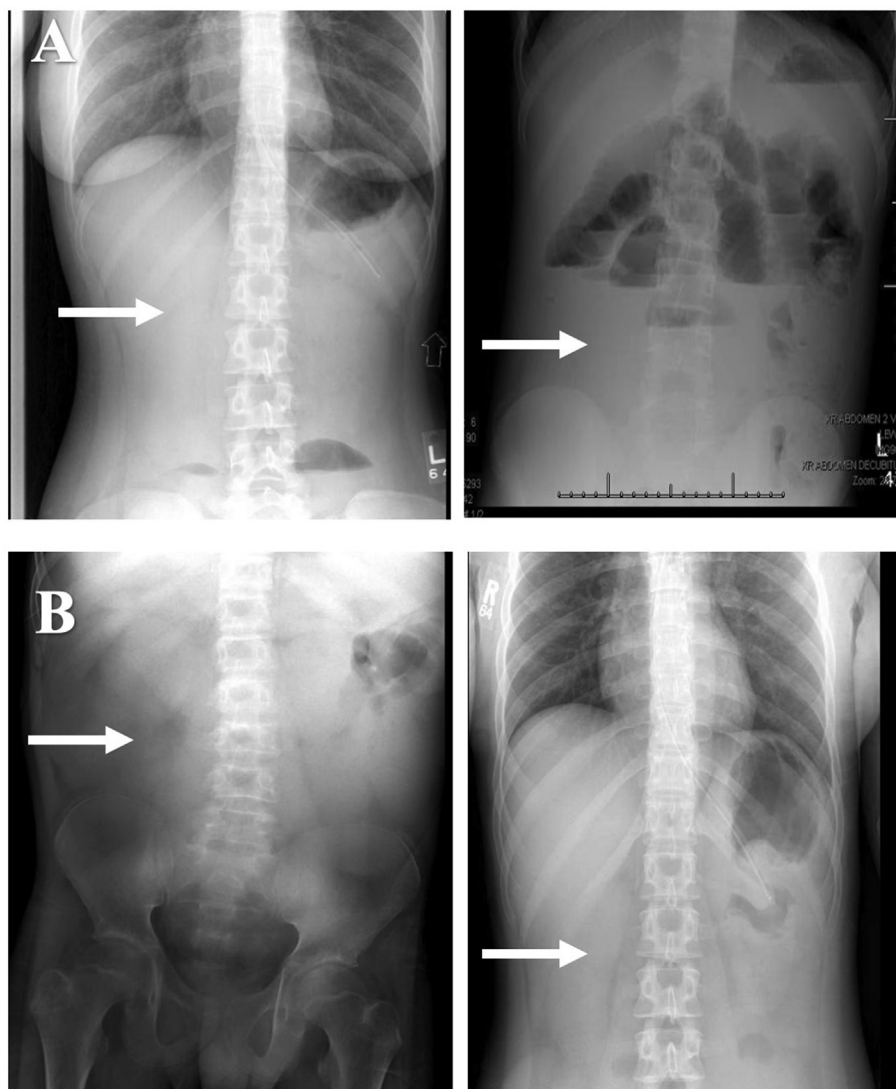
Two patients with paucity of gas AXR (supine and upright films). Arrows point to the areas of the radiographs where paucity of gas was noted.
